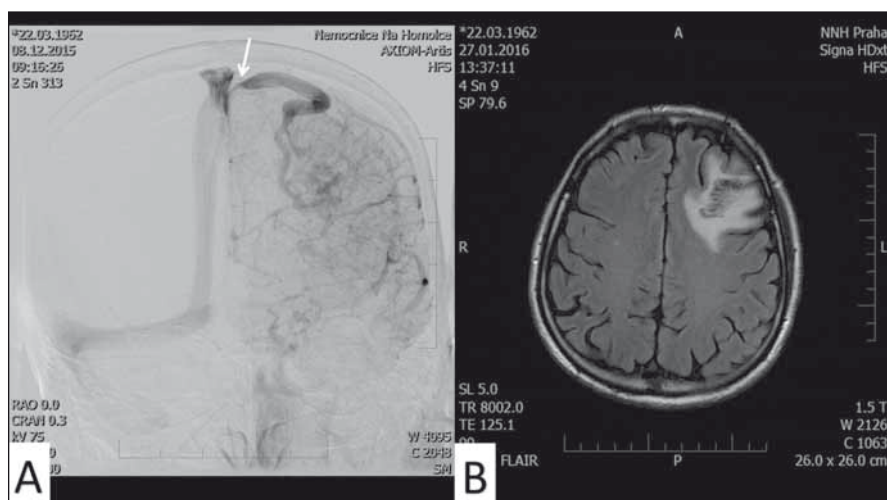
Preoperative MRI and DSA examination.
